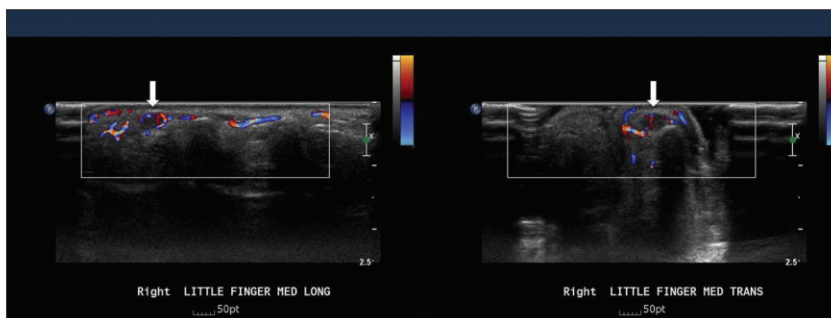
Longitudinal (right) and transverse (left) ultrasonograms of the right little finger show markedly hypoechoic about 4 × 6 mm sized mass-like lesion in the ulnar aspect of distal phalanx. Color doppler shows hypervascular mass.
